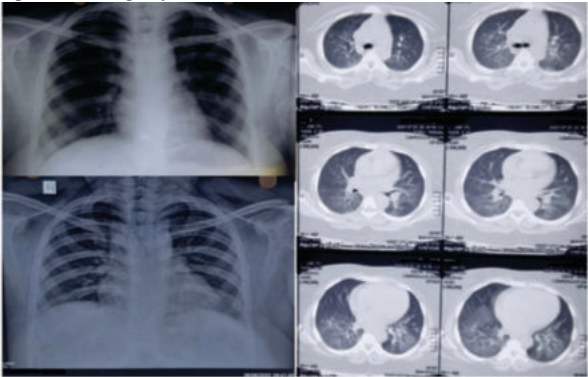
Chest X-ray taken 5 years during RA diagnosis and now after ILD
